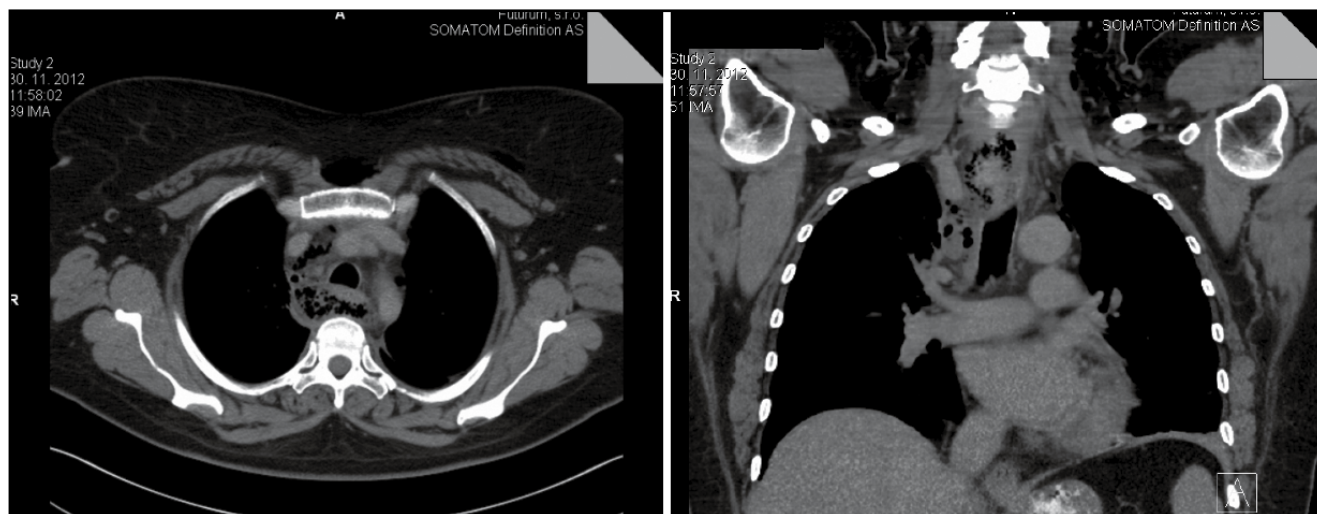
CT scan 3 days after surgery: pneumomediastinum, fluid collection around the gas bubbles in the mediastinum – highly suspected mediastinitis.
